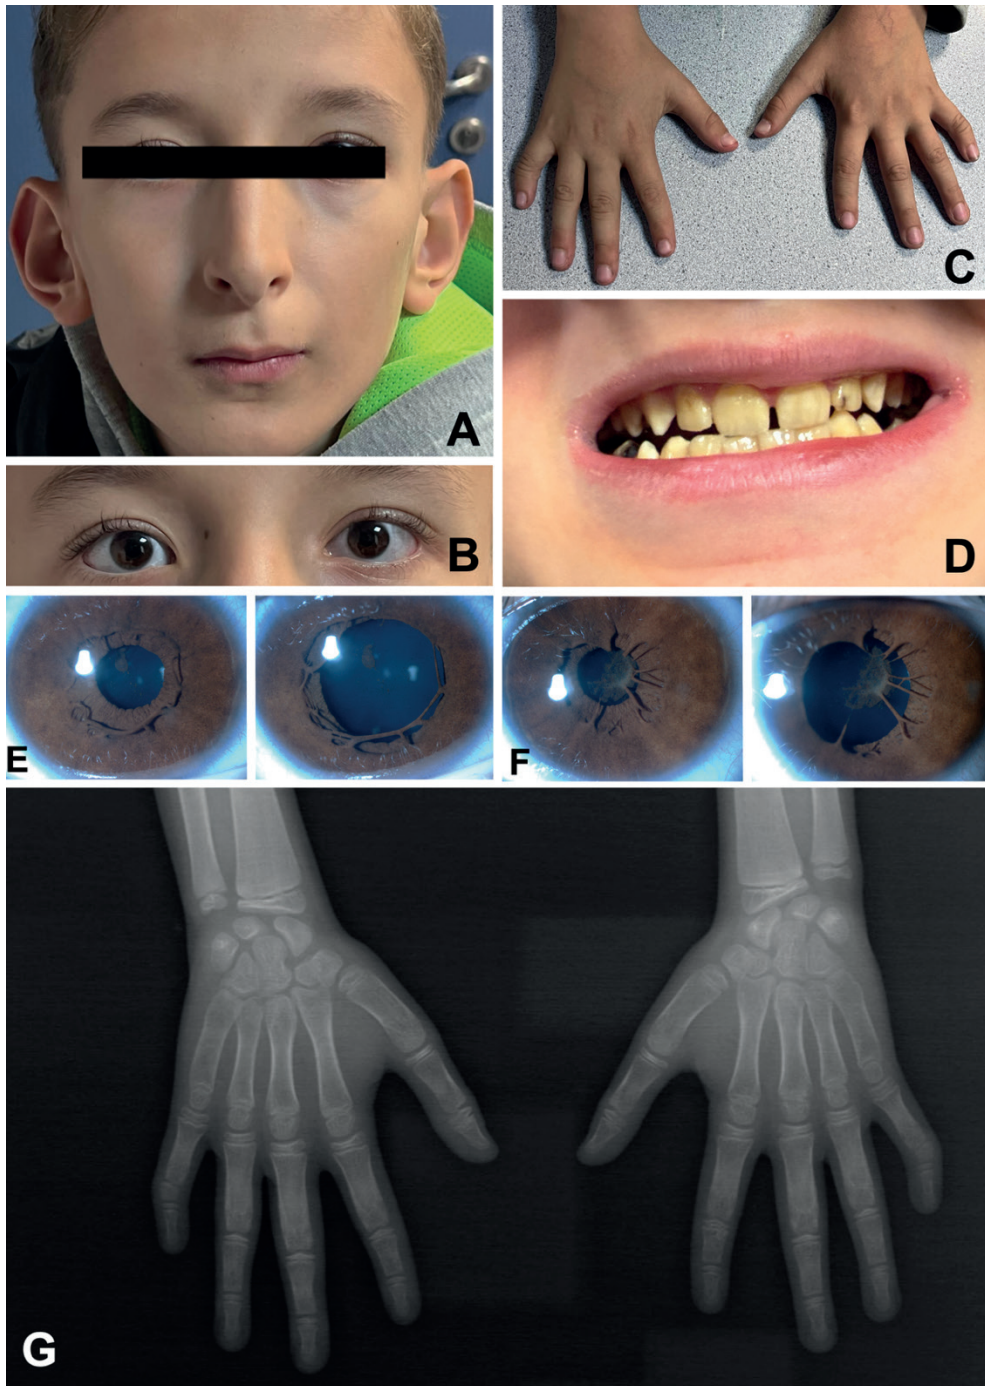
(A) Craniofacial features including a narrow, pinched nose with hypoplastic alae nasi, prominent columella, and low-set, anteverted ears. (B) The photograph of the eye demonstrates mild microcornea. (C) Bilateral clinodactyly of the fifth fingers. (D) Clinical photograph showing multiple dental caries, yellow discoloration and enamel hypoplasia. (E, F) Slit-lamp photographs revealing iris strands extending toward the anterior lens capsule, consistent with mild persistent pupillary membrane. Iris strands adherent to the pupillary margin in a pharmacologically dilated pupil, along with irregular pupillary contours. (G) Bilateral hand radiographs demonstrate clinodactyly of the fifth digits.
